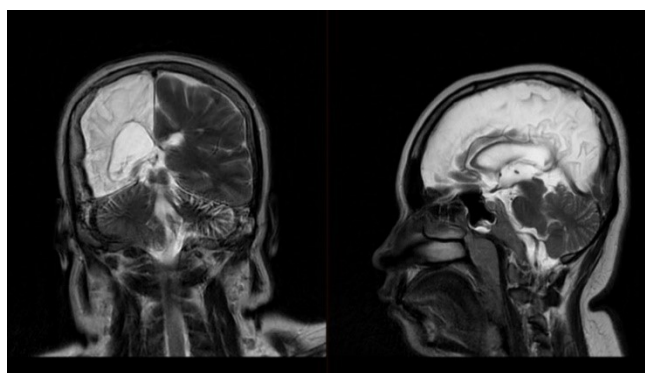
Coronal and Sagittal Brain Epilepsy MRI (Dyke- Davidoff-Masson syndrome with crossed cerebellar atrophy)
